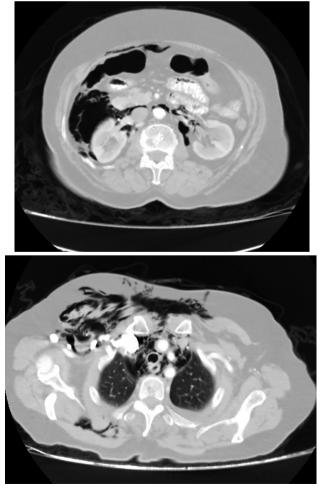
Pneumoperitoneum, pneumomediastinum, pneumothorax and diffuse subcutaneous emphysema on computed tomography
